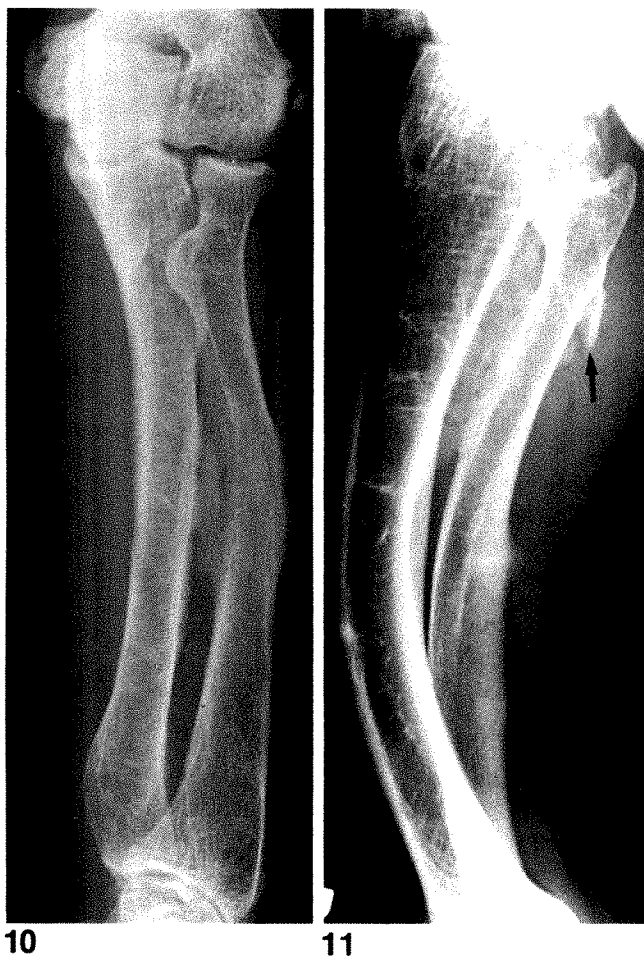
Radiograph shows marked cortical thickening at radial attachment of interosseous membrane, prominent radial tuberosity, and proliferative changes at lateral epicondyle with a small accessory ossicle laterally.
